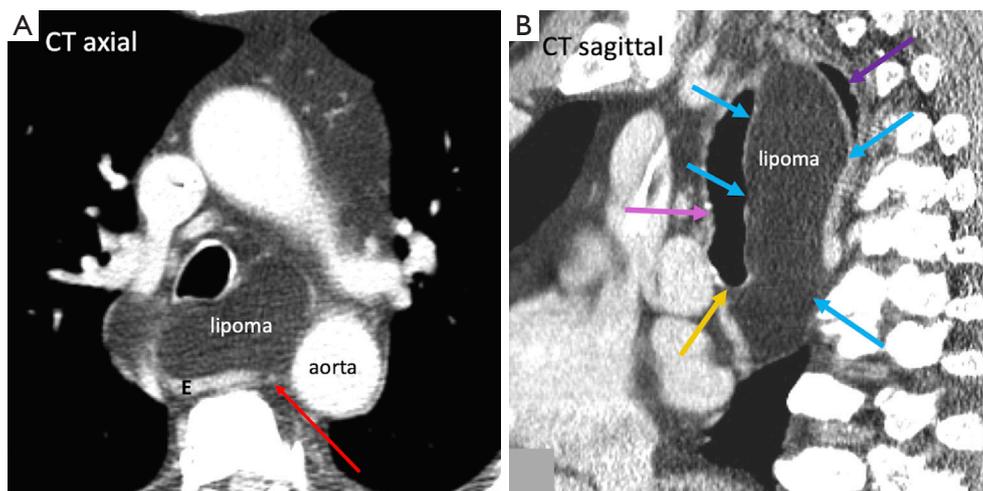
A 65-year-old male patient with mediastinal lipoma. (A) Axial contrast-enhanced chest CT image shows lipoma being limited axially by aorto-esophageal ligament (red arrow), E: esophagus. (B) Sagittal CT chest image shows lipoma (blue arrows) extending along the peri-esophageal space, displacing the trachea (pink arrow) and esophagus (purple arrow). Lipoma continues longitudinally below carina (orange arrow). CT, computed tomography.
